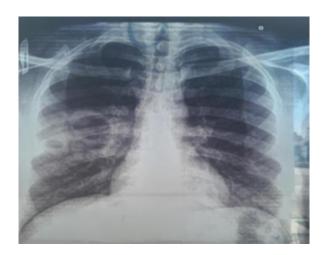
Chest radiograph of pulmonary tuberculosis (Hôpitaux généraux Hakim Saadane, 2023).
